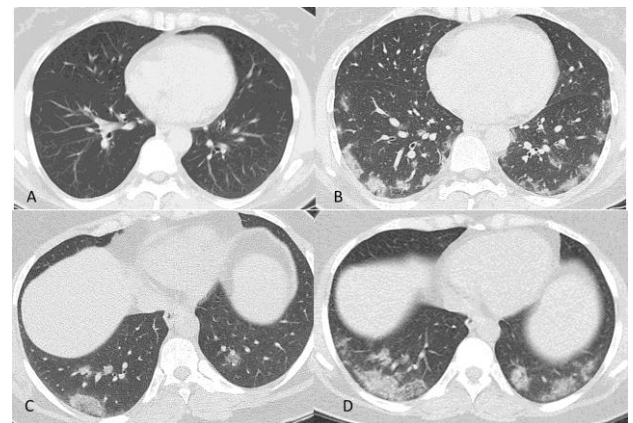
A 50-year-old female patient who presented with shortness of breath had no COVID-19 pneumonia findings on the axial slices of the non-enhanced chest CT (A) performed on the day of onset of symptoms, while the CT of the same patient performed after 11 days showed peripheral consolidation area located in the lower lobes of both lungs and round GGO density (B) in the middle lobe of the right lung and the lingular segments of the left lung. A 44-year-old female patient who presented with malaise had consolidation areas located in the lower lobe of the right lung and GGO density in the lower lobe of the left lung (C) on the chest CT performed on the day of onset of symptoms, while the 6-day CT of the same patient showed an increase in consolidations visualized in the lower lobe of the right lung, and the GGO density in the lower lobe of the left lung turned into consolidation with air bronchogram (D).
